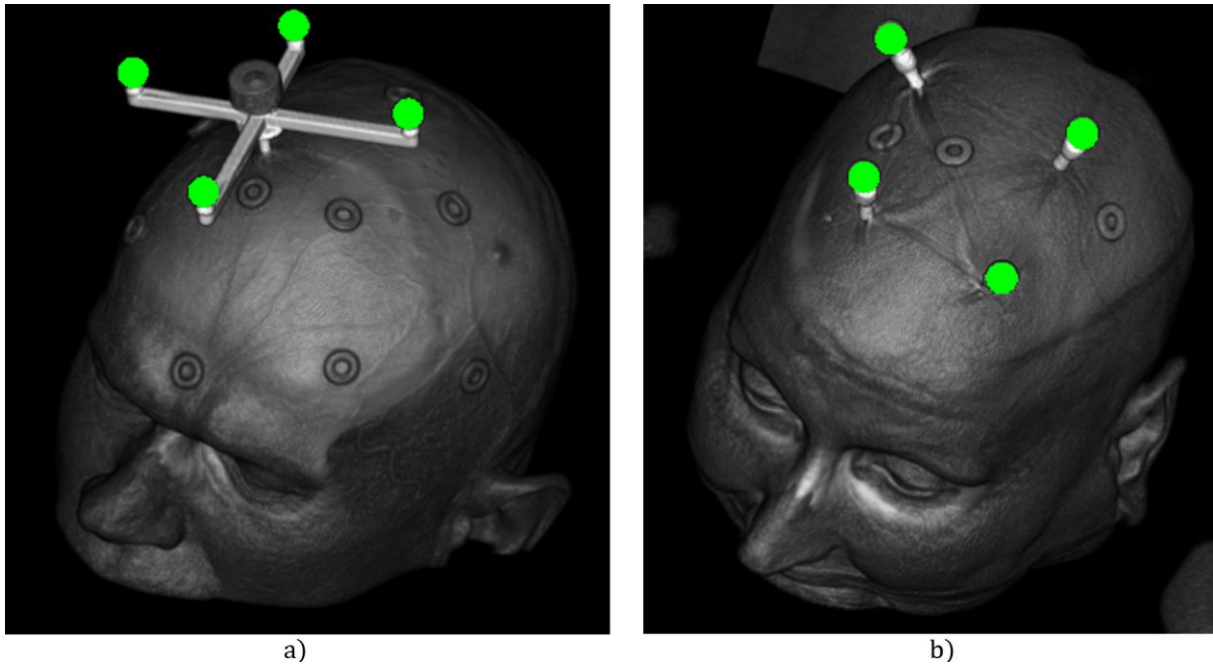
Localized fiducial markers highlighted in a CT scan: a) x-shaped frame, b) Freely distributed markers
